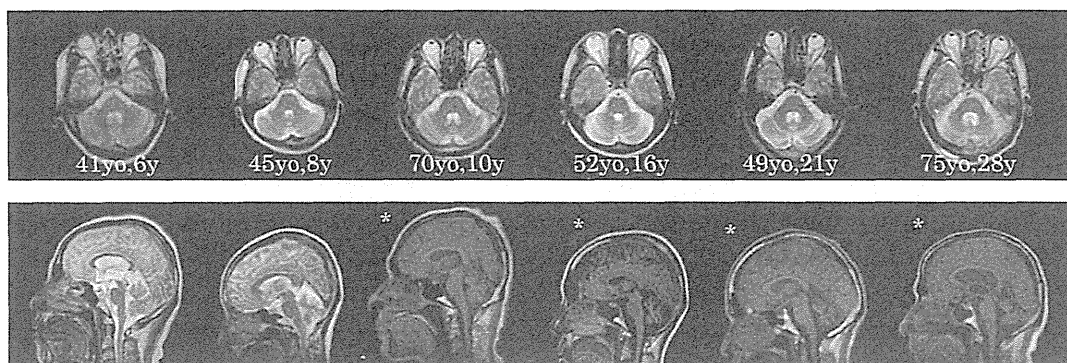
MRI T₂ weighted image (axial, sagittal 1.5 T; TR 4,600 ms, TE 85 ms) of six SCA31 patients (upper rows) and six SCA6 patients (lower rows). T₁ weighted image (sagittal, TR 520 ms, TE 15 ms) were shown in four SCA6 patients (*).
